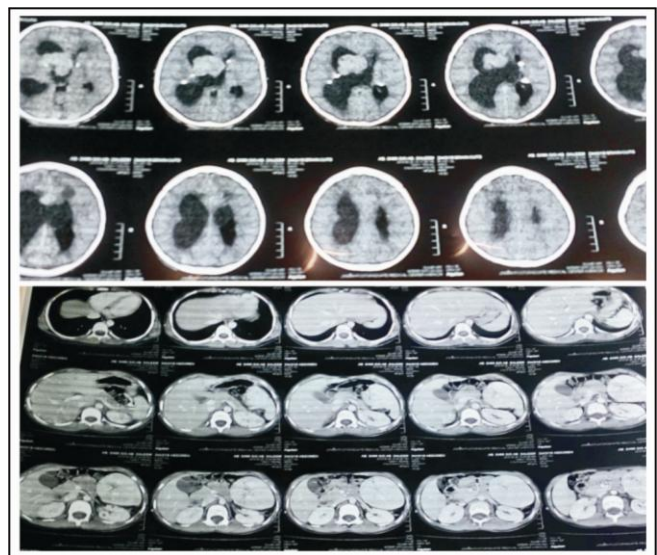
CT Brain showing subependymal nodules and giant cell astrocytoma. CT Abdomen showing nonrenal abdominal hamartoma.
